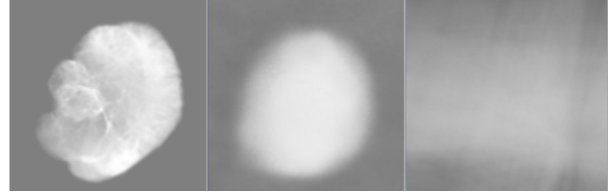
Comparison of outputs across models. Left-most picture is the ground-truth slice. Middle picture is slice rendered by the MRI-based network. Right-most picture is the slice generated by original PixelNeRF trained on natural images.
